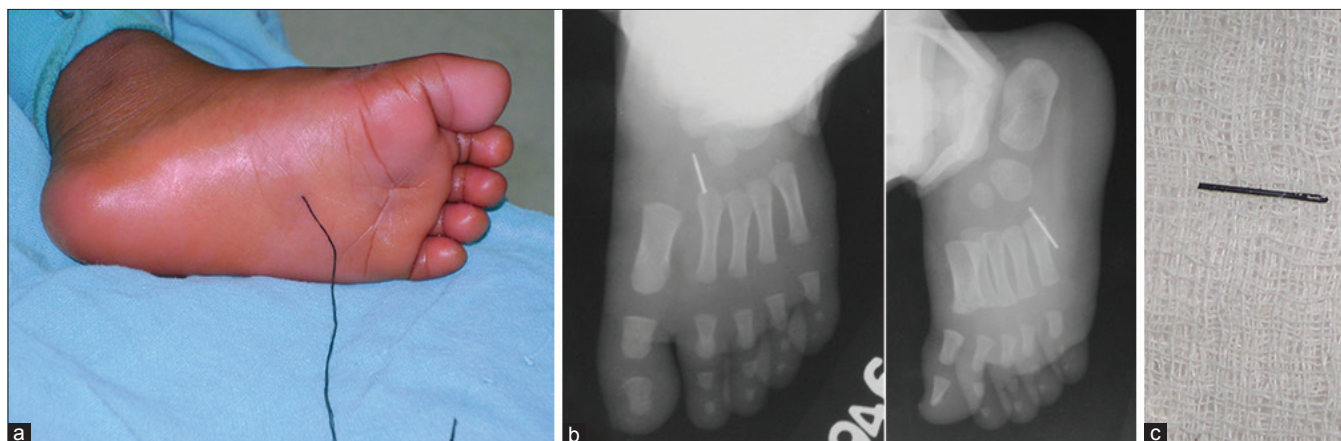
(a) Clinical photograph showing the most common metallic foreign body-metallic sewing needle. In this particular case, the thread was the telltale sign. (b) Plain radiographs of foot anteroposterior and oblique views showing metallic foreign body - sewing needle. (c) Extracted needle
